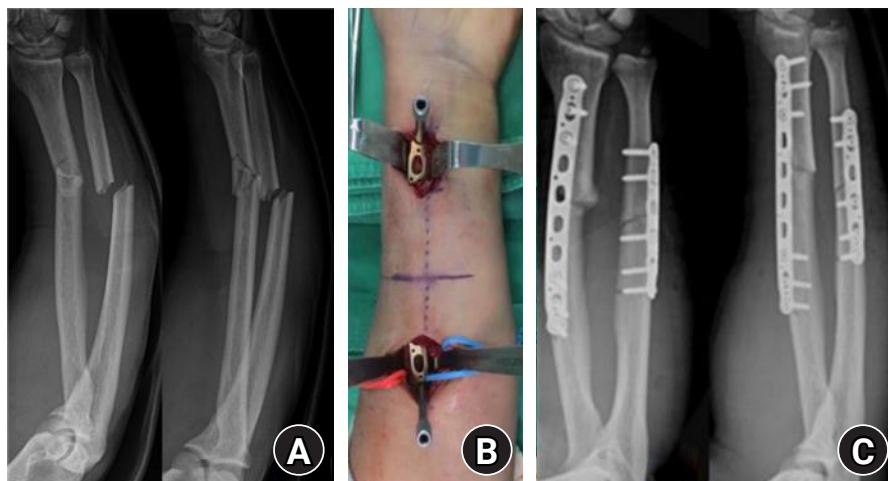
A 43-year-old female patient with a comminuted radial shaft fracture treated with minimally invasive plate osteosynthesis. (A) Preoperative radiographs. (B) Intraoperative clinical photograph demonstrating external distractor-assisted indirect reduction. (C) Immediate postoperative radiographs after bridge plating using minimally invasive plate osteosynthesis.
